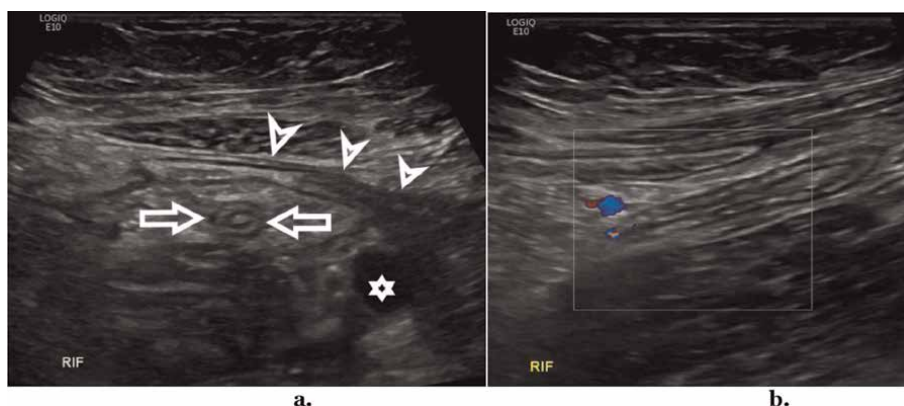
Sonograms of the normal appendix from the same patient. A: The normal appendix (between arrows) in a transverse orientation; note the 'target' appearance and the longitudinal segment of the terminal ileum (TI) coursing anterior to the appendix (arrow heads), and the iliac artery (star). b: The longitudinal segment of the appendix in a longitudinal orientation, with no appreciable flow seen on colour Doppler; also note the terminal ileum in an oblique orientation anterior to the appendix and the psoas posteriorly.
